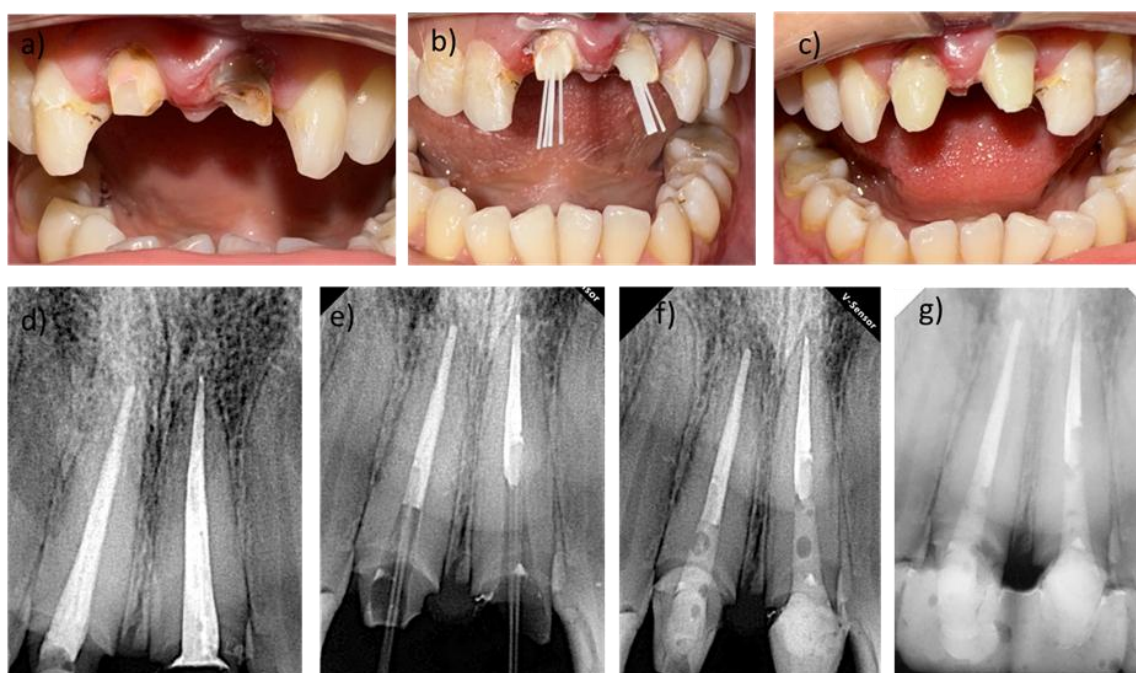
Visual of case 1, a) Initial intraoral view, b) Intraoral view with bundle post inserted, c) Intraoral view of the core structure, d) Radiograph after root canal treatment, e) Bundle post control radiograph, f) Post-core restoration radiograph, g) 3-months follow-up radiograph
